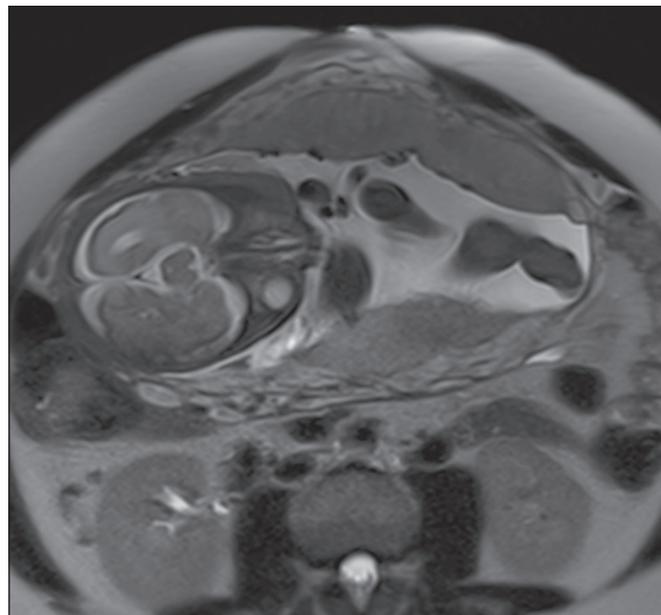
A 38-year-old patient with no signs of placenta accreta. Axial T2-weighted HASTE sequence showing uterine bulging in the umbilicus due to abdominal diastasis.
